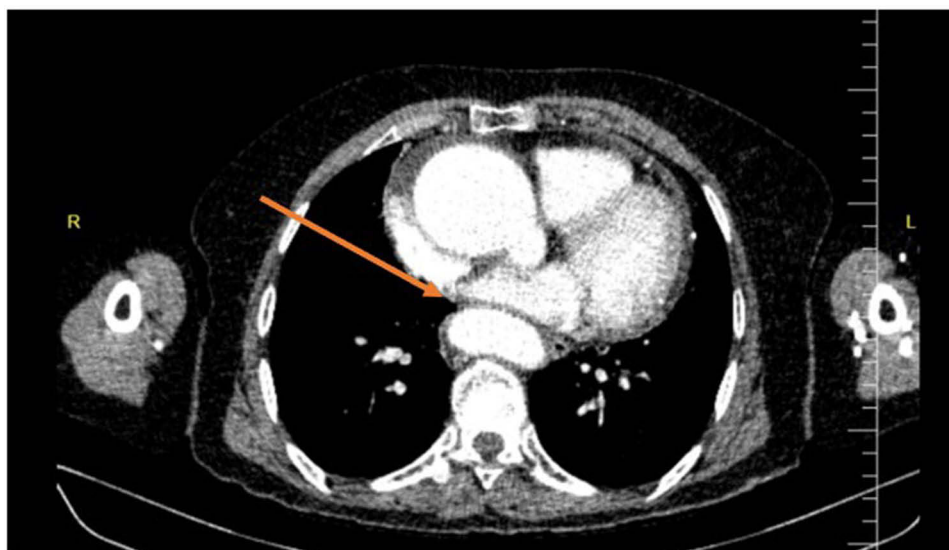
A CT image at the mid-thoracic level showing the esophagus completely compressed by the descending aorta. The Orange arrow indicates the site of complete esophageal compression.
